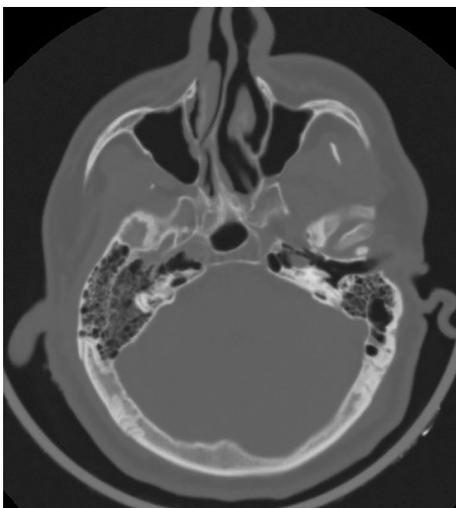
Right cerebral hemiatrophy, increased calvarial thickness on the right, and hyperaeration of the mastoid bone in a 28-year-old male patient (CT).
